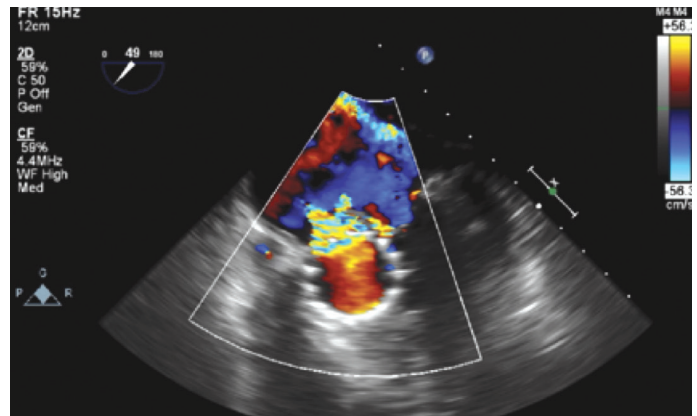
Echocardiography at 40th day.
